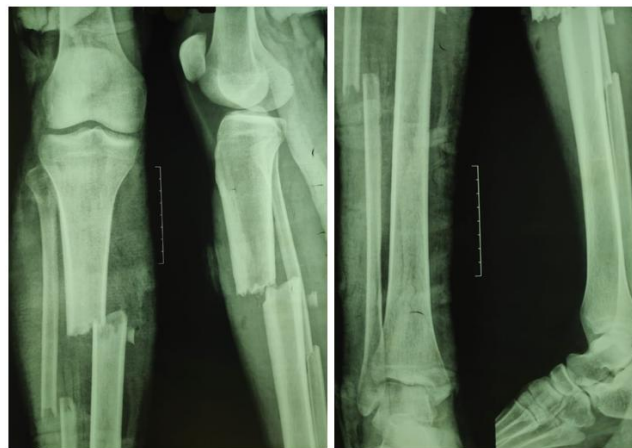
Xray of case 1 showing compound fracture of both bones of leg
